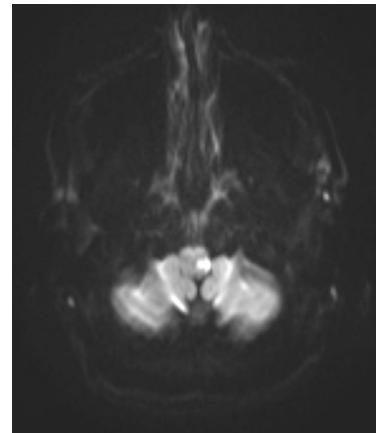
Axial diffusion-weighted magnetic resonance imaging of the head demonstrates restricted diffusion in the left posterolateral medulla, consistent with posterior inferior cerebellar artery territory ischemia.
